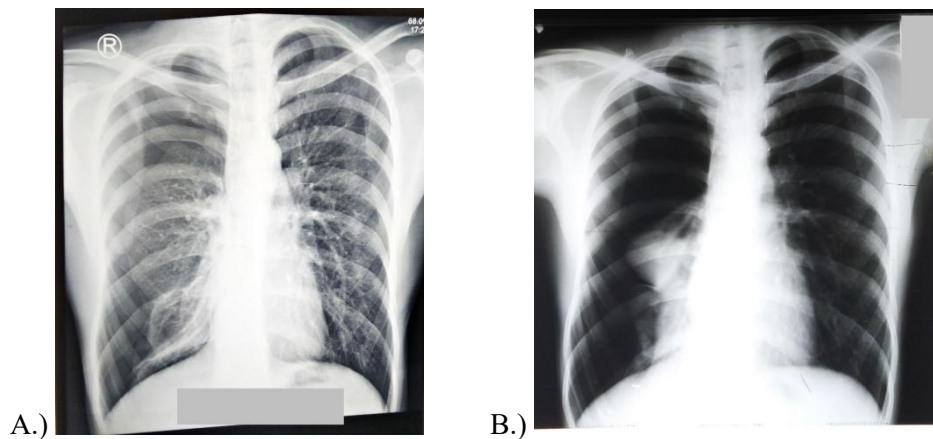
A.) Chest X-ray 9 days ago shows a total right pneumothorax B.) Chest X-ray in the emergency room shows the right lung has partially expanded
